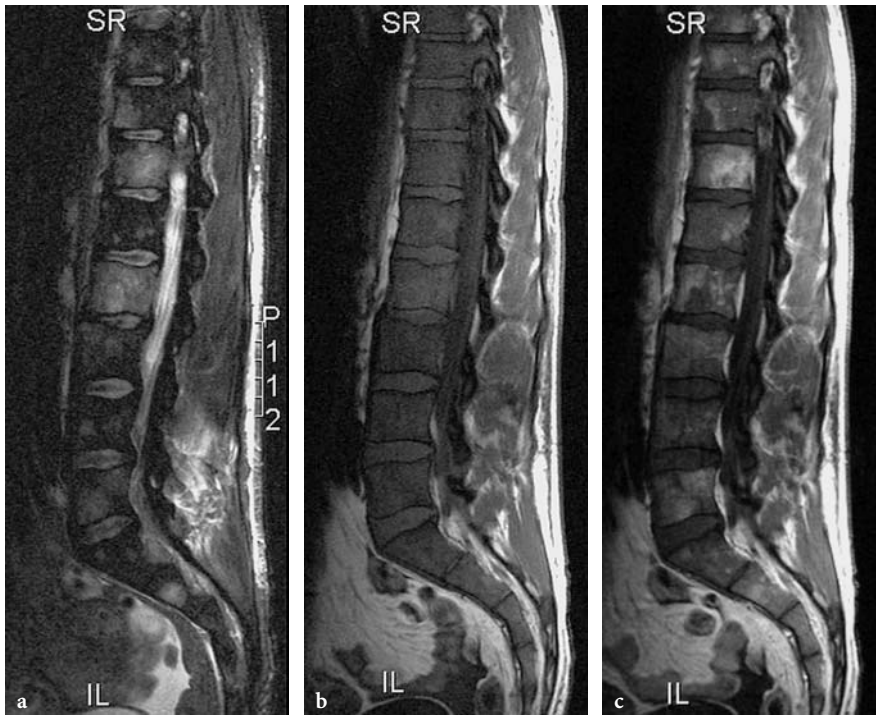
Sagittal STIR (a), T1-weighted SE (b) and Gd-enhanced T1-weighted SE (c) images in a 40-year-old patient with an anaplastic cutaneous T-cell lymphoma. Note the multifocal diffuse bone marrow involvement (a,c) and the diffuse low signal of the bone marrow (b)
